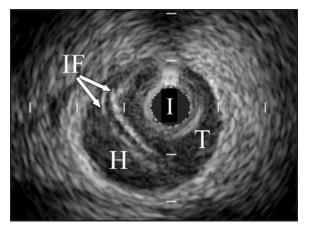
Intravascular ultrasound of the mid segment of the left anterior descending artery demonstrates a coronary dissection with intimal flaps (IF), an intramural hematoma in the false lumen (H), and a diminished true lumen (T).
